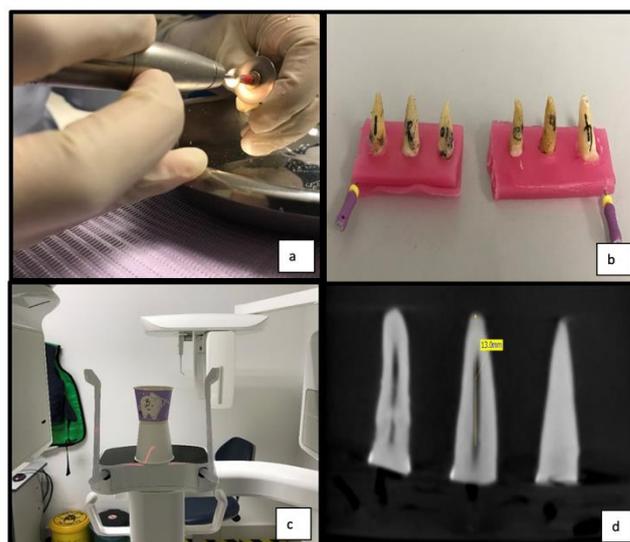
a) Sectioning of tooth at the cemento-enamel junction using a disc. b) Mounting of teeth on wax block (after cleaning and shaping) prior to scanning with CBCT. c) Mounted samples to be scanned using the CBCT machine. d) The measuring of the vertical distance from tooth apex using an orthogonal view from CBCT scans.
